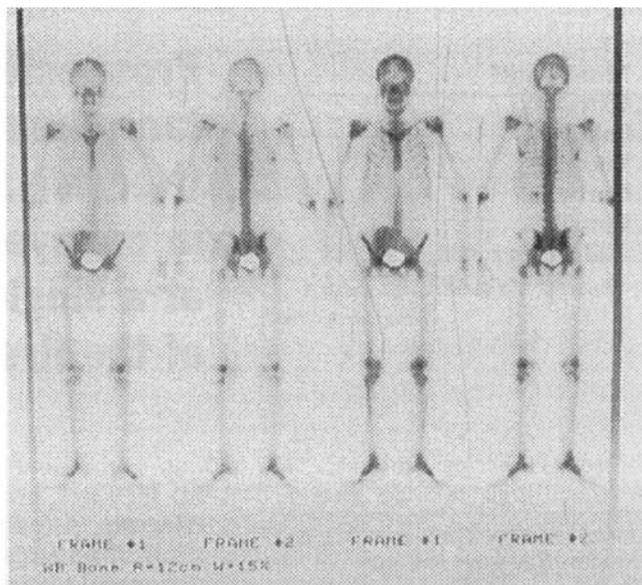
Bone scanning with ^{99m}Tc methylene pyrophosphate: complete recovery of scintigraphic findings (the same patient as in Fig. 2)
